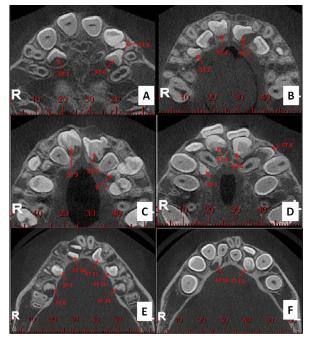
CBCT image showing 7 supernumerary teeth in the maxilla (A–D) and 7 in the mandible (E–F).
